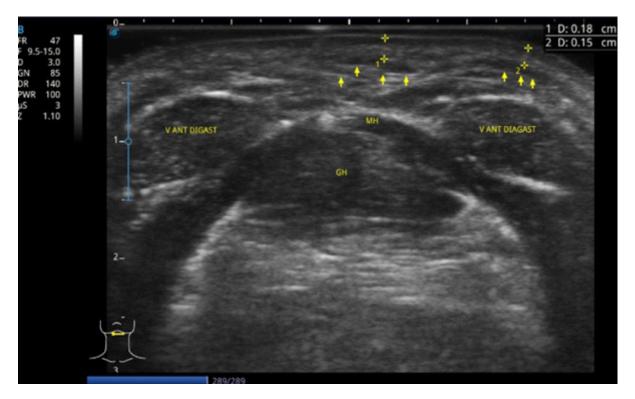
Ultrasound image showing regression improvement in fibrosis after 120 days.
